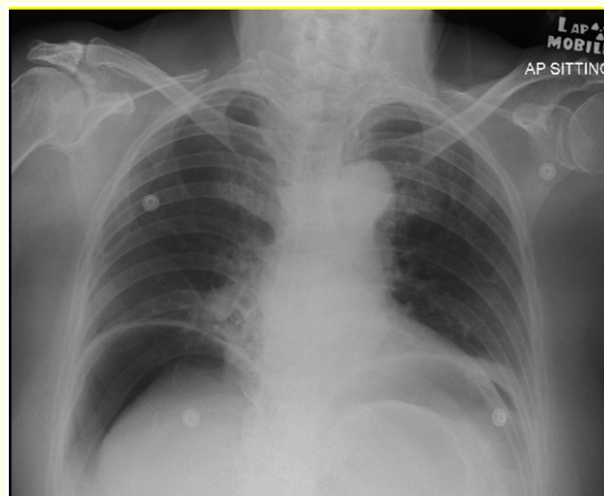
(Erect chest x ray) Arrow showing extensive air under diaphragm on erect chest radiograph.
